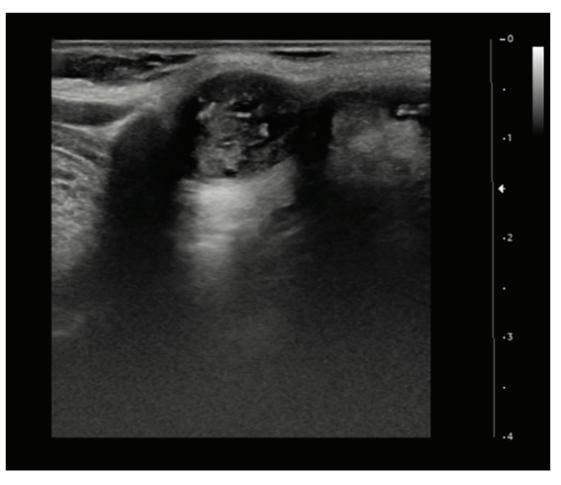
A well-defined, complex, mildly vascular nodule of 15x11x9 mm is seen in the midline of the neck on the inferior surface of the hyoid bone in a 43-year-old male, ultrasound imaging (Case 9).
